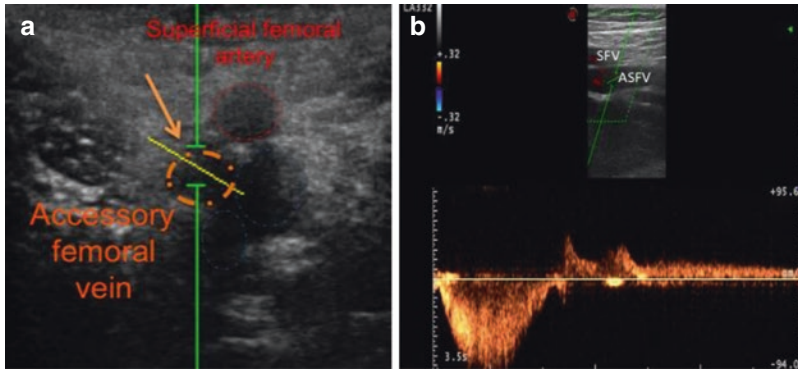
(a) Duplicated femoral vein (orange dotted line, accessory femoral vein) at the confluence with the femoral vein. (b) Reflux documentation with the ultrasound in PW mode (With permission from [8])
